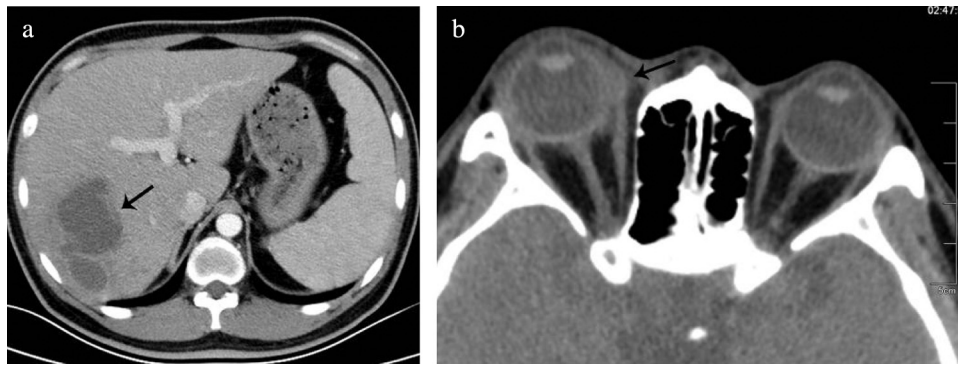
Images of a 34-year-old man with diabetes who presented with fever and right eye swelling for 3 days. (a) Contrast-enhanced CT showed a single abscess in the left lobe of the liver (arrow), which was predominantly cystic in appearance. Abscess and blood cultures were positive for *K. pneumoniae*. (b) CT showed the right side of the thickened peri-orbital wall (arrow).
